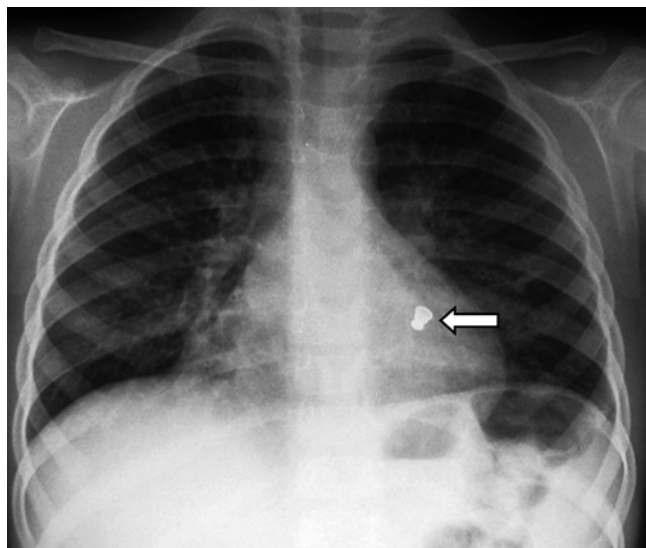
Radiopaque foreign body in the left lower lobe bronchus in a 4-year-old boy who presented with acute onset of coughing and respiratory distress. After chest radiographs, the patient underwent bronchoscopy, which showed a metallic bottle cap lodged in the left lower lobe bronchus. Frontal chest radiograph shows a radiopaque foreign body (*arrow*) located in the left lower lobe, retrocardiac region (Reprinted with permission from *Seminars in Roentgenology*, page 183, Volume 47, No. 2, 2012)
